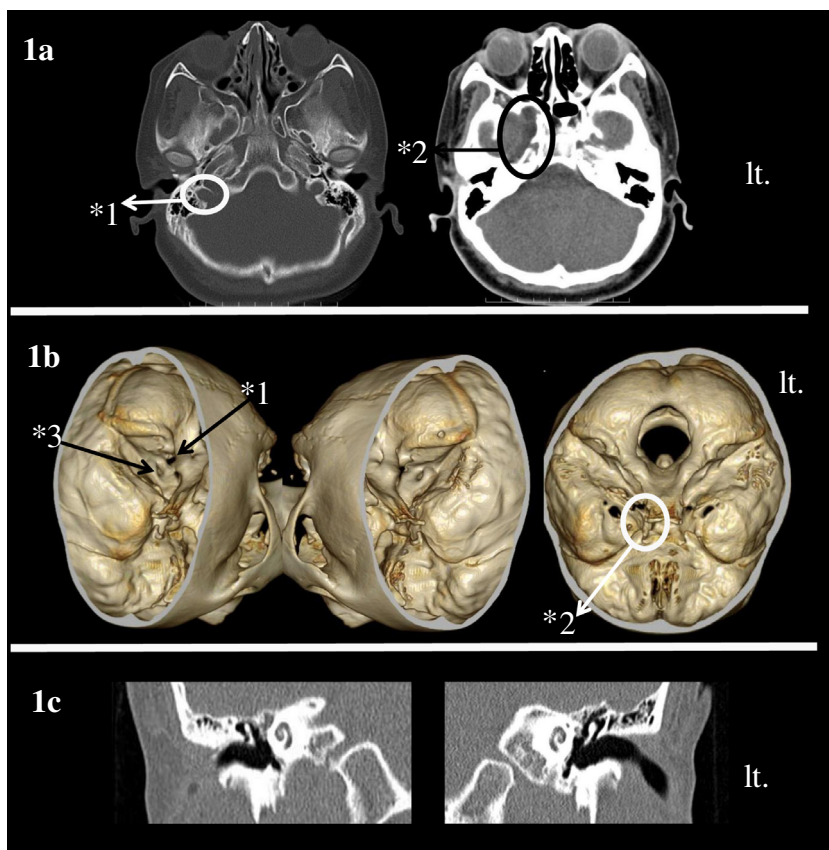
Head and Ear CT. (1a) Head CT scan: Cystic expansion of the right jugular vein hole (*1) and Meckel's cavity expansion was observed (*2). (1b) Head 3D-CT: Expansions of the right jugular foramen (*1), internal acoustic pore (*3), and Meckel's cavity (*2) were observed. (1c) Ear CT scan: No obvious internal ear malformation was observed.
